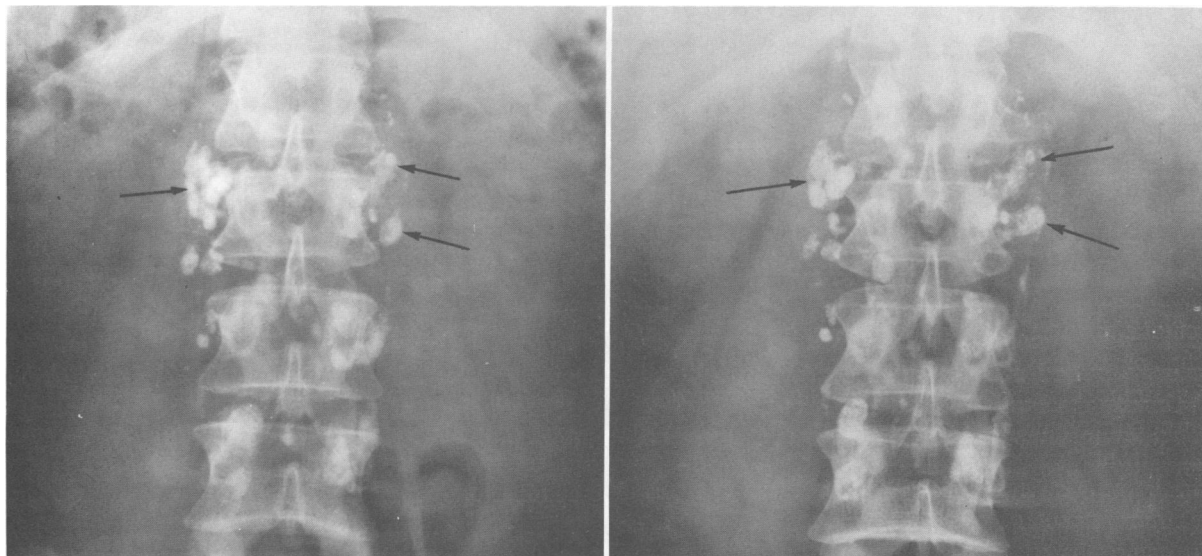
Left, preoperative lymphangiogram interpreted as normal. No surgical clips were used. Right, the lymph nodes to the left and right of the second lumbar vertebral body have become roentgenographically abnormal by enlargement and displacement. Arrows indicate the nodes which demonstrated the major changes.
